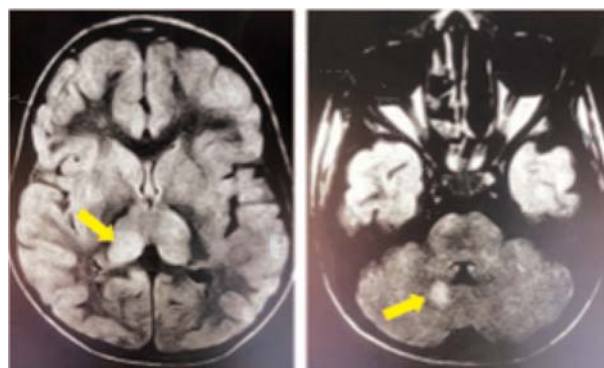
(A-C) Axial FLAIR MRI Images showing multifocal patchy areas on T2 (arrows).
